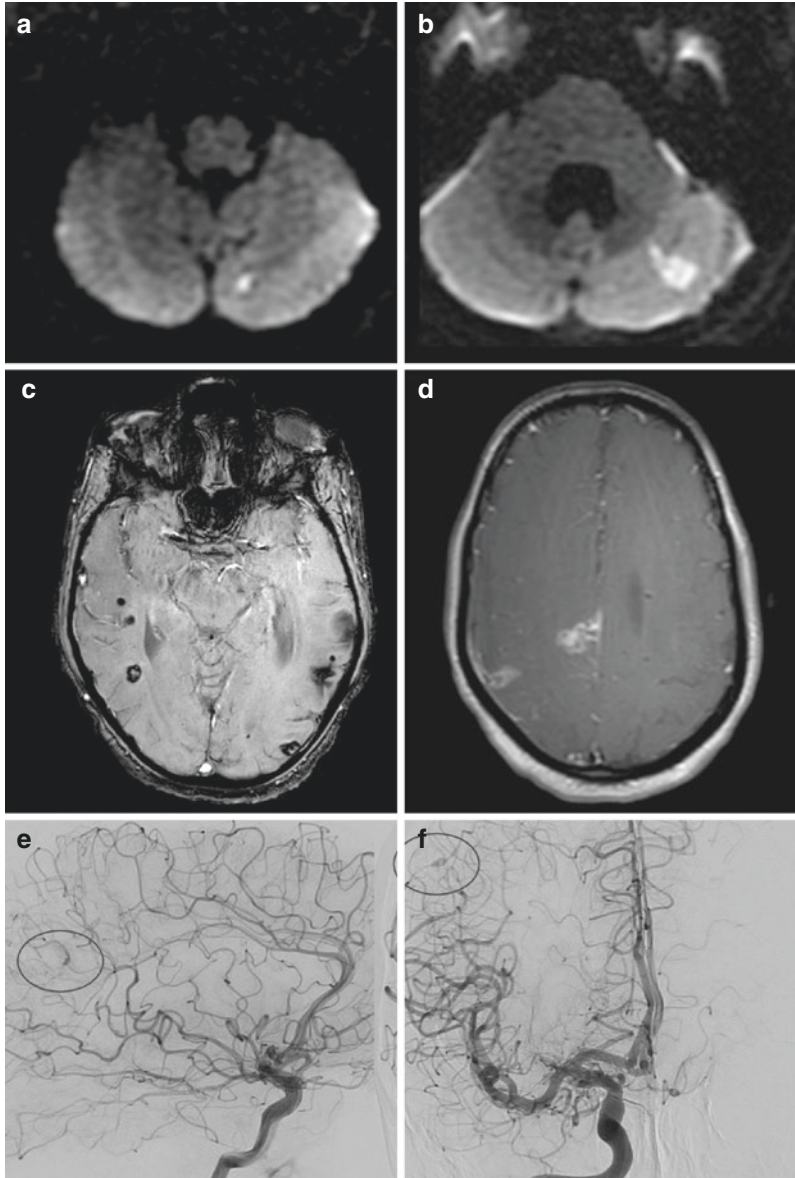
Ischemic, hemorrhagic and infectious cerebral complications in a 40-years old patient with mitral valve endocarditis due to *Streptococcus salivarius*. (a, b) diffusion-weighted MRI showing multiple hyperintensities corresponding to recent cerebellar infarctions. (c) susceptibility-weighted imaging showing hypointensities corresponding to deep and superficial micro-hemorrhages (or cerebral microbleeds), associated with subarachnoid hemorrhages due to a ruptured mycotic aneurysm (non-visible on MR angiography), and hemorrhagic transformation of an ischemic lesion. (d) gadolinium-enhancing T1 lesions corresponding to cerebral abscesses. (e) mycotic micro-aneurysm located in a distal segment of the left middle cerebral artery. (f) mycotic micro-aneurysm located in a distal segment of the right middle cerebral artery
